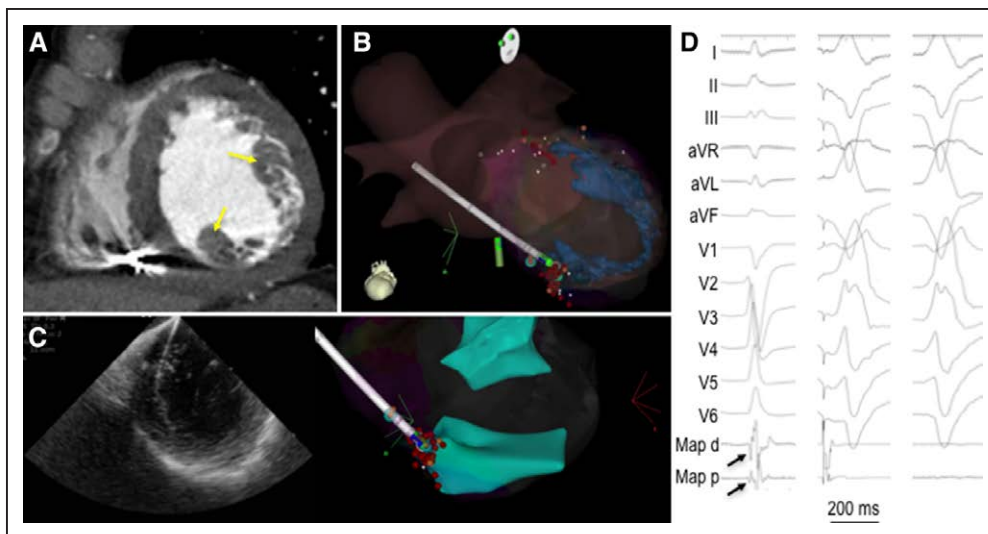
Example of combining intracardiac echocardiography and CT to assist catheter navigation in a case with papillary muscle PVC.
